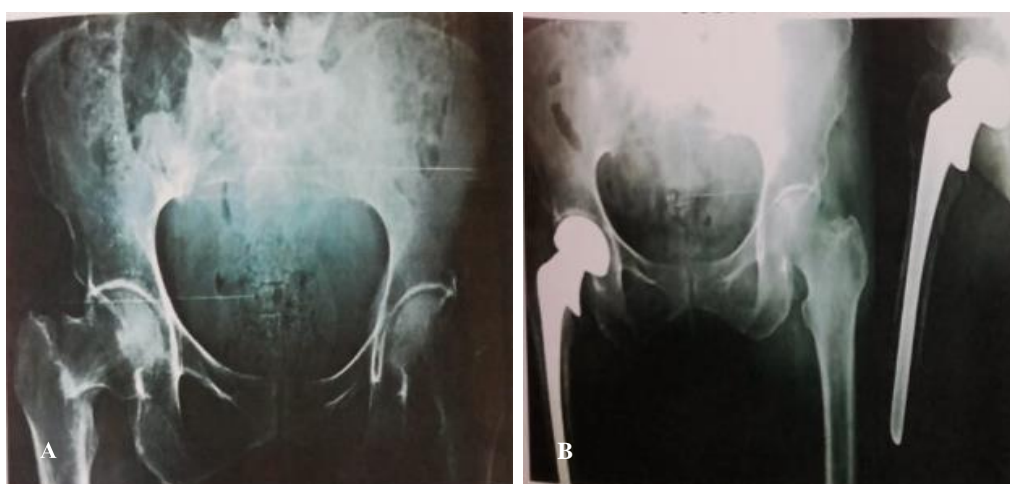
(A and B) Preoperative and follow-up X-ray (uncemented bipolar case).
